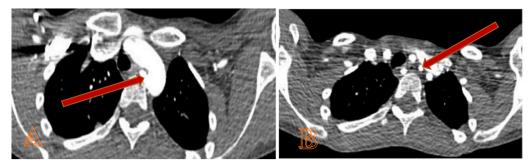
a and b A contrast-enhanced CT scan performed for surgery planning and shows: (A) a non-aneurysmal arteria lusoria (red arrow) and (B) compressed and narrowed esophagus (red arrow).
